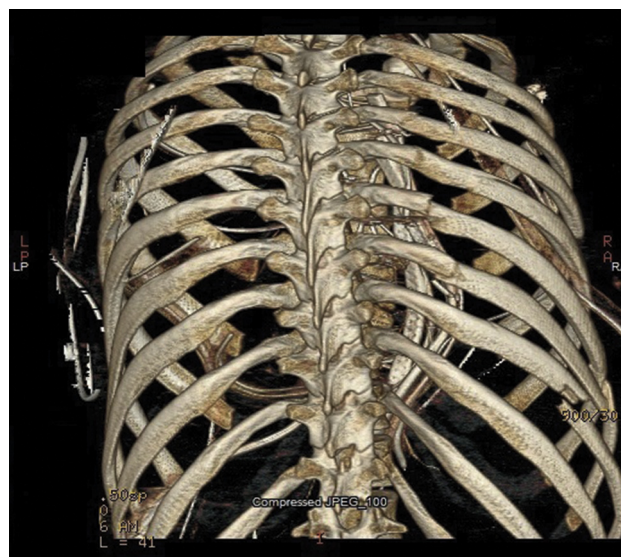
Posterior three-dimensional computed tomography image of the chest wall with associated rib fractures.
